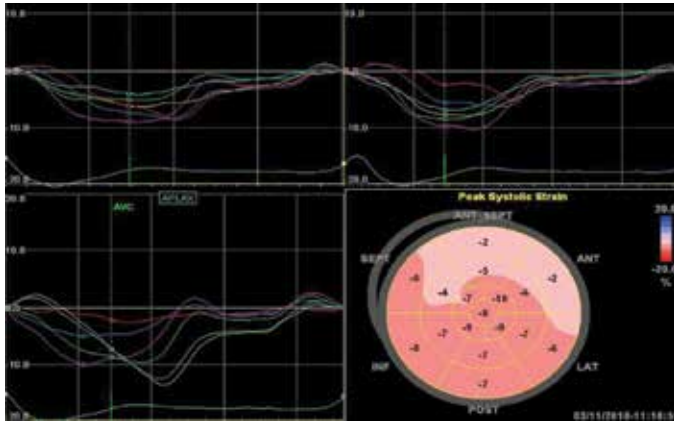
Bull-eye demonstration of reduced left ventricular peak systolic strain value by 2D speckle tracking echocardiography.
